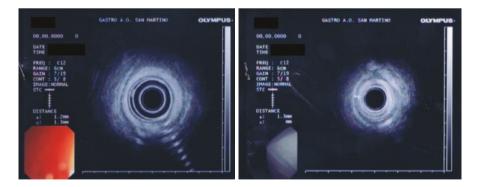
Transrectal endoscopic ultrasonography. "External anal sphincter echo structural normal. Internal anal sphincter without interruption of continuity, but of reduced thickness, (about 1.3 mm measured at about 9 o'clock and three in correspondence of the middle part of the anal canal)"
